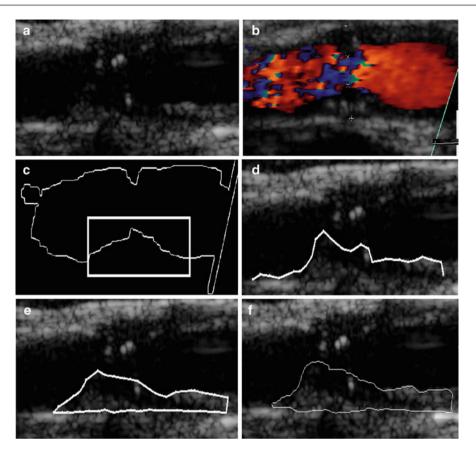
Plaque initialization using the blood flow image: (a) original ultrasound B-mode image of a carotid artery with plaque at the far wall, (b) blood flow of the image in (a), (c) initial blood flow edge contour with the area for the initial contour selected by the user, (d) sampled
